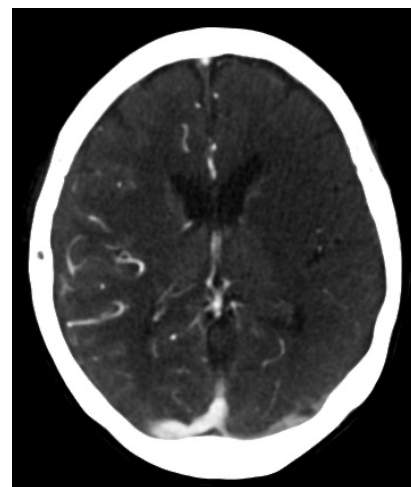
CT cerebral angiogram showed lack of blood flow to the left cerebral hemisphere
